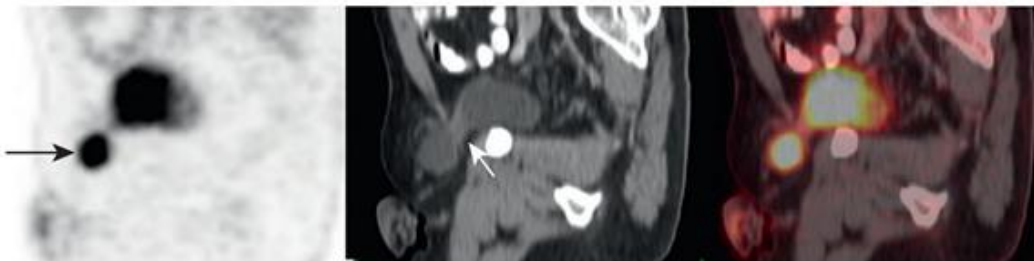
Sagittal FDG PET, CT, and fused FDG PET/CT through the pelvis of the same patient as Fig. 1.5. The FDG focus in the right inguinal region is again seen on the PET-only images (*arrow*). The sagittal CT image demonstrates the herniation of the bladder through an inguinal hernia (*short arrow*). The CT helps characterize the FDG focus in the right inguinal region as a benign bladder hernia, rather than malignancy.
